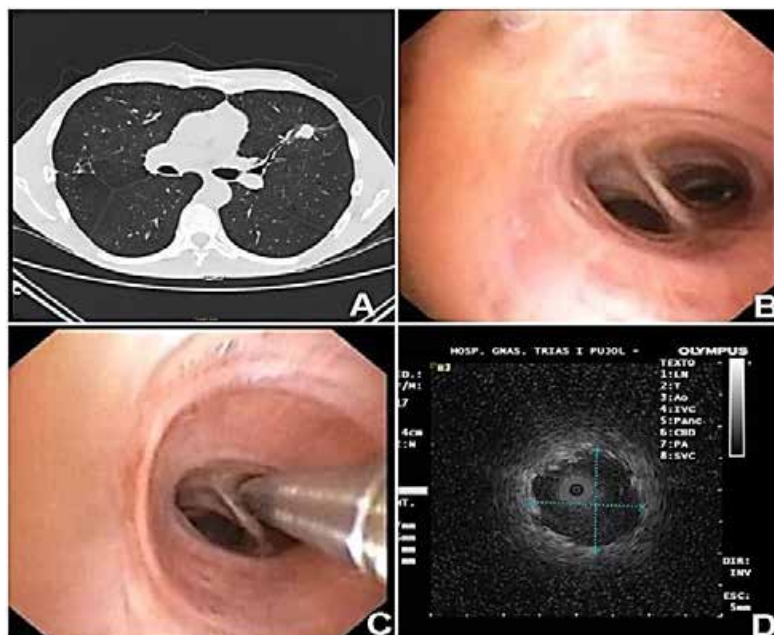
(Case 1): A) Thoracic CT showing a solitary nodule in the left upper lobe. B) White light image for the airways by bronchoscope. C) Radial probe EBUS rotating in the target segment in contact with the bronchial walls. D) Ultrasound image of the nodule captured and measured.
